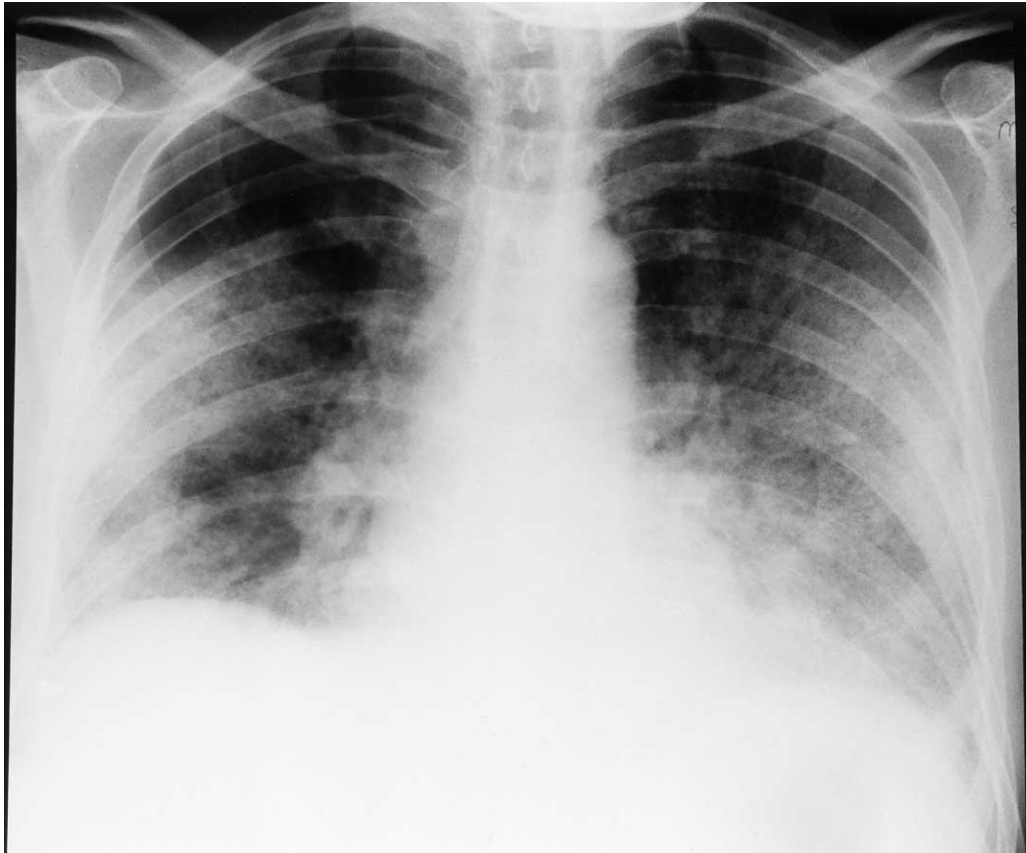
Radiograph of the chest of patient 1, who had orbital and sinus aspergillosis, showing bilateral fluffy infiltrates that occurred in association with confusion and hypoglycemia on day 6 after commencement of voriconazole therapy.
